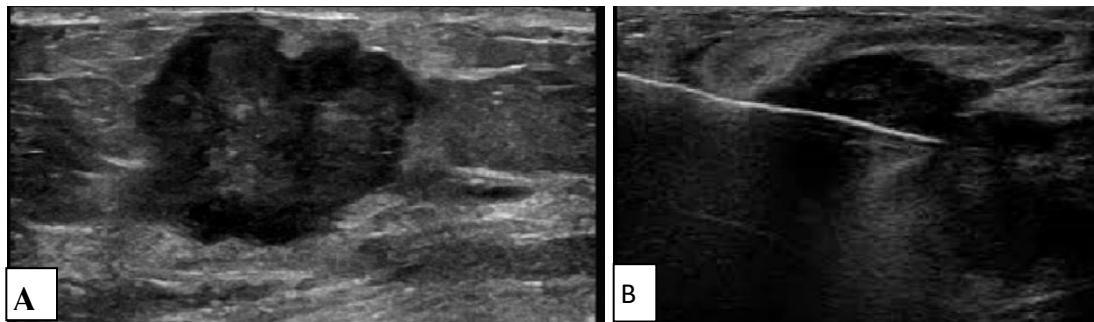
49-years-old female presented by a right breast mass, with no family history of breast cancer. Breast ultrasound was done and revealed irregular hypo echoic mass lesion at the UOQ
